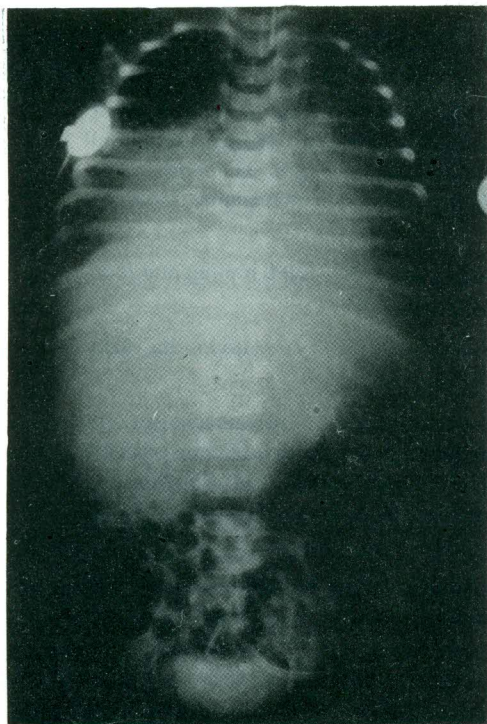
Preoperative chest x-ray shows the tumor occupying the most of the right hemithorax and extending to the left. Patient is intubated.
